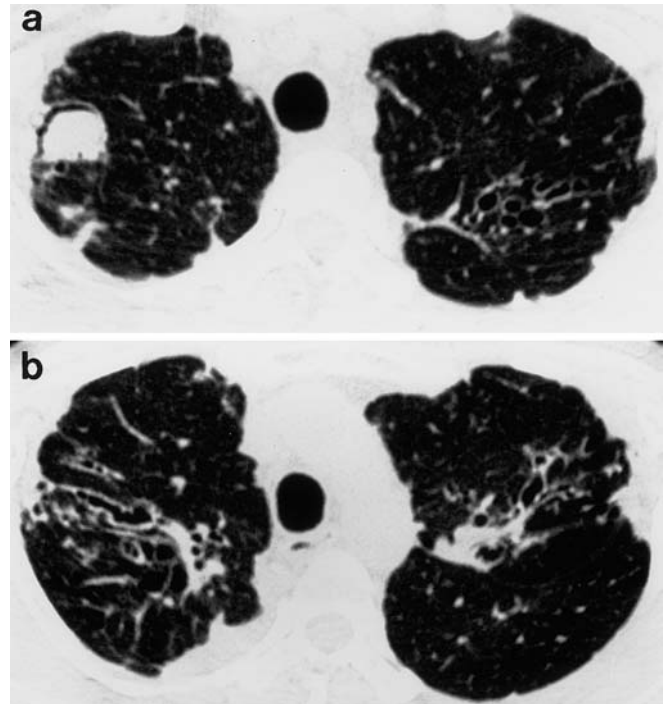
Co-existent aspergilloma in a patient with longstanding allergic bronchopulmonary aspergillosis shown on HRCT. a An aspergilloma in the right upper lobe, with typical proximal bronchiectasis seen in b ABPA on an adjacent section
